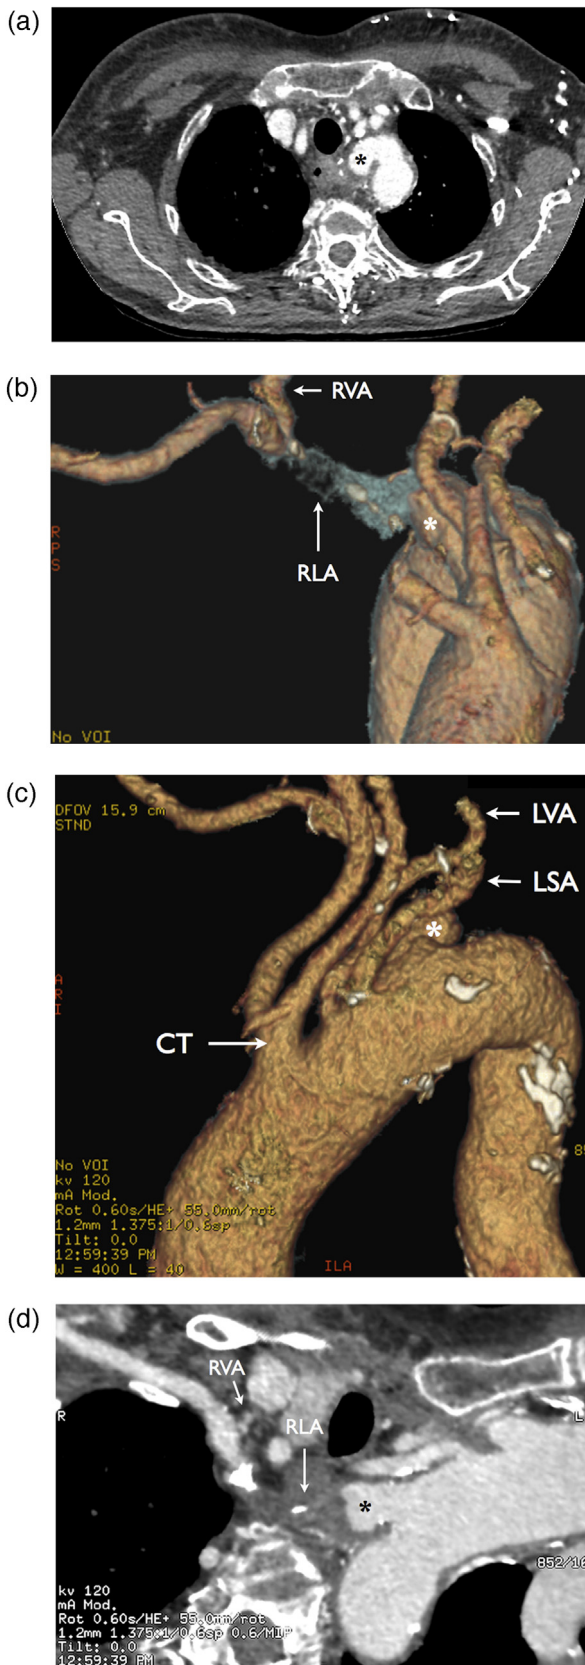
Baseline MDCT examination. (a) Axial source image, (b, c) Volume Rendering and (d) Curved Planar views show patent KD (*) associated with thrombosed prevertebral right lusory artery (RLA), autonomous origin of the left vertebral artery (LVA) from the aortic arch, and origin of both common carotid arteries from a short common trunk (CT). The proximal portion of the right vertebral artery (RVA) is patent, as well as the RLA distal to it. LSA = left subclavian artery.
